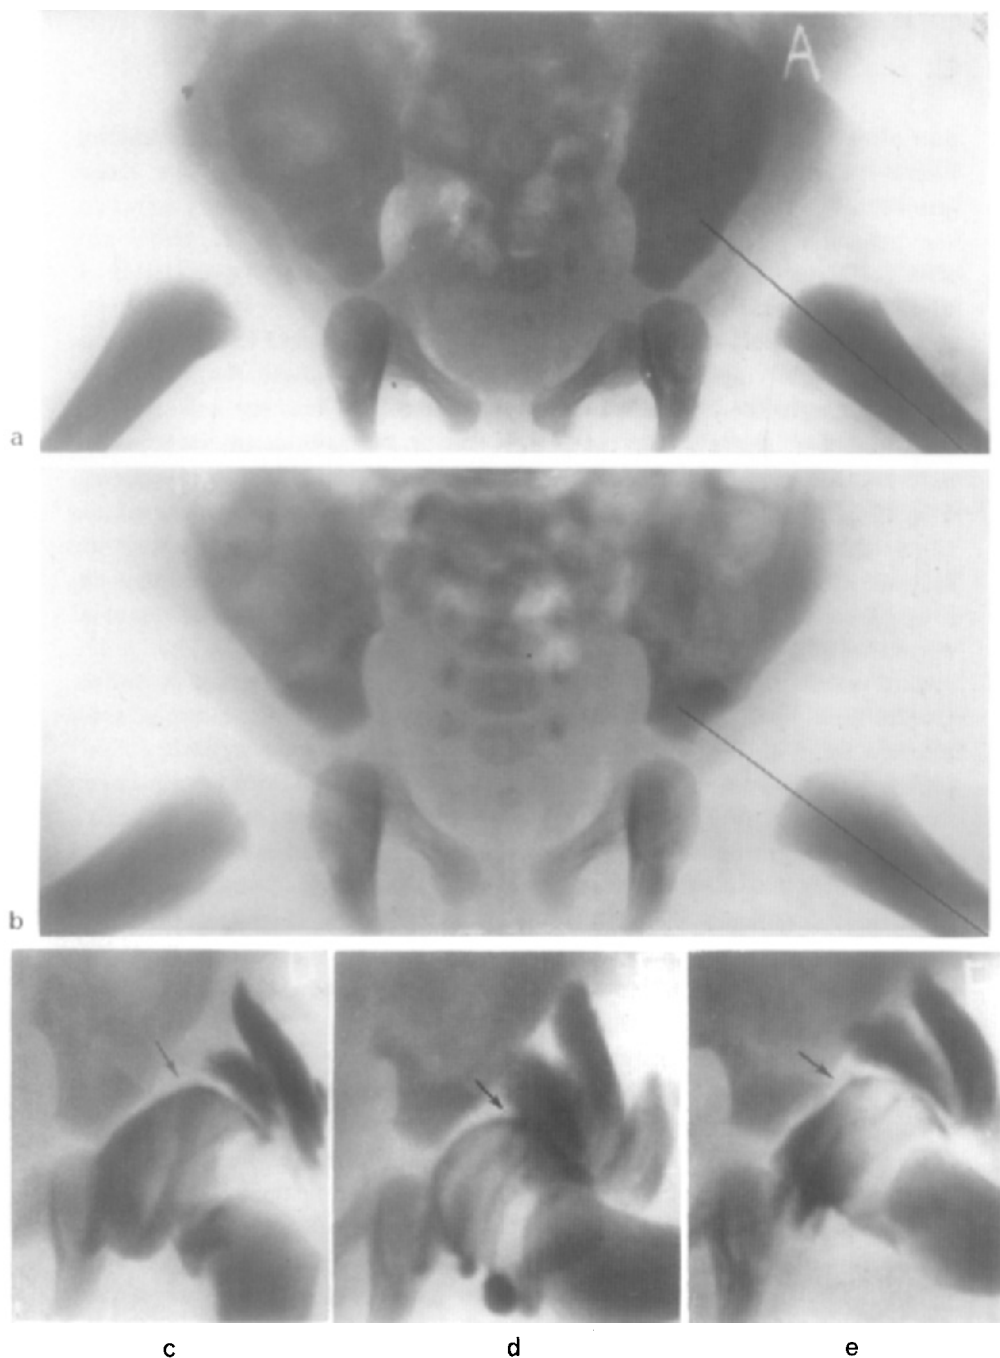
Limitation of X-ray diagnosis
